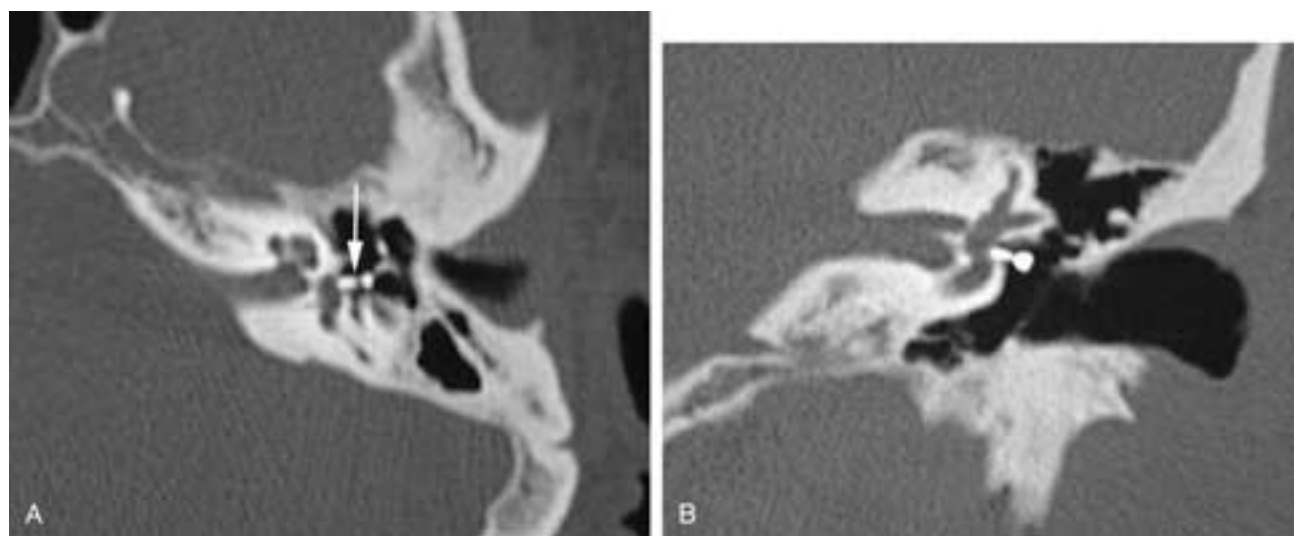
Fenestral otosclerosis after stapedotomy. A, Axial CT image of the left ear shows a prosthesis (*arrow*) inserted into the oval window. Otosclerotic plaque is noted anterior to the oval window. B, Coronal CT image of the left ear demonstrates the prosthesis. Note that the end of the prosthesis protrudes minimally into the vestibule.
